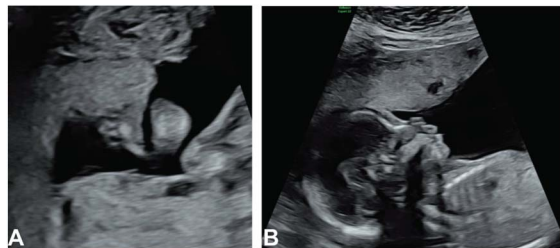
Normal lip and palate. A. Second-trimester coronal ultrasonogram with a normal nose and lips. Palate not visualized. B. Second-trimester sagittal ultrasonogram with normal nose, lips, and palate.
